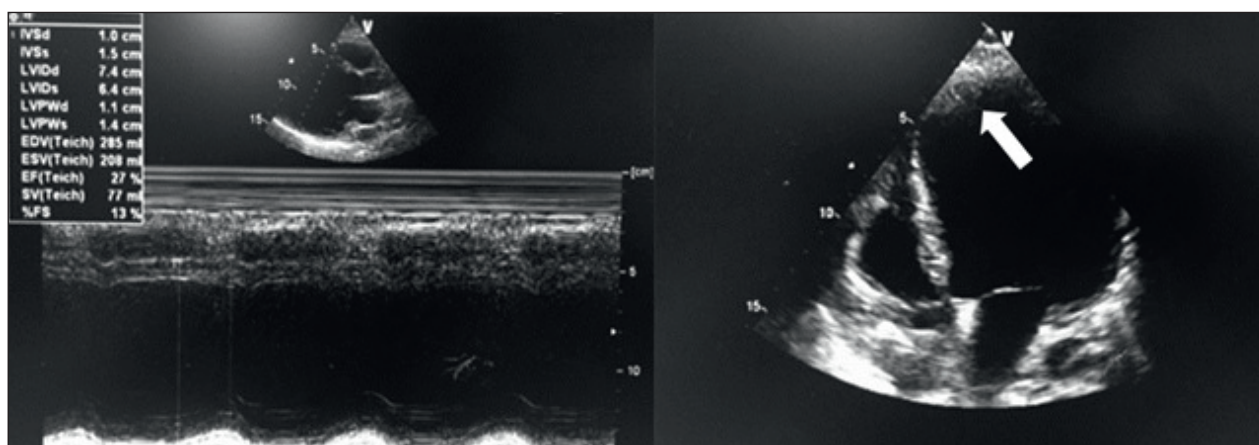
Echocardiographic findings six months after ICD-CRT implantation. Epicardial resynchronization therapy did not induce improvement in left ventricular ejection fraction and reverse remodeling. Please note a blood clot (thrombus) in the left apical ventricle (white arrow).
